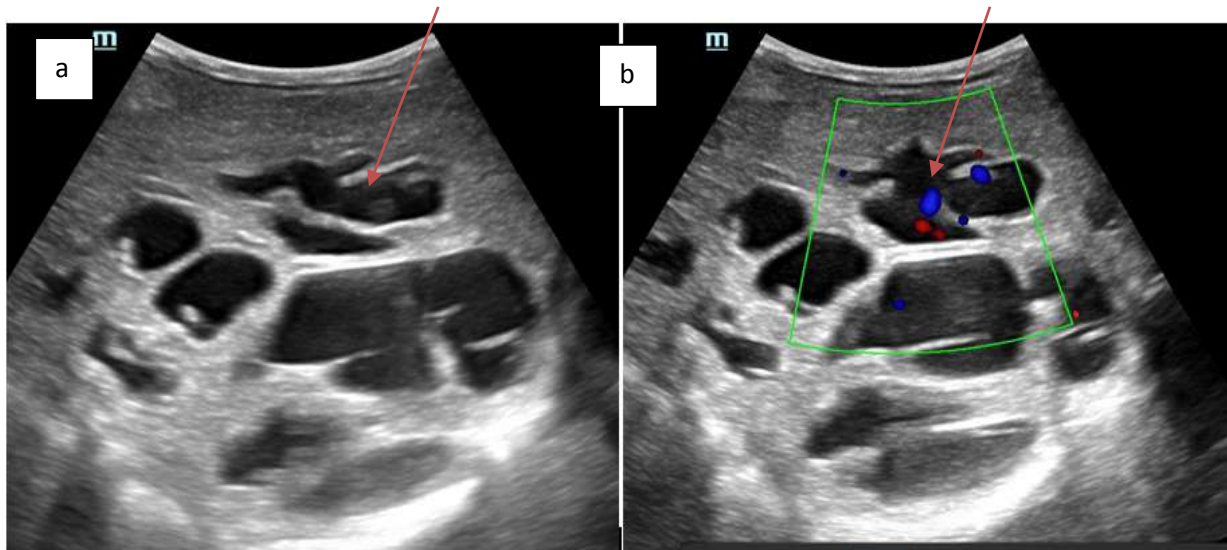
(a) Sagittal section of right lobe of liver showing IHBR dilatation (Gray scale USG), (b) Axial section of scrotum showing internal vascularity inside dilated IHBR (Colour Doppler study).
